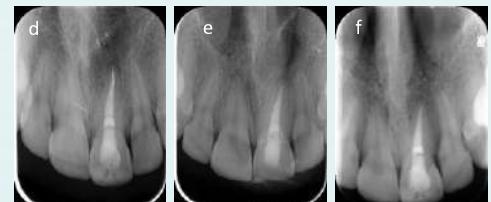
Periapical radiographs of #21 at 6 (d), 12 (e) and 24 (f) month control session.
